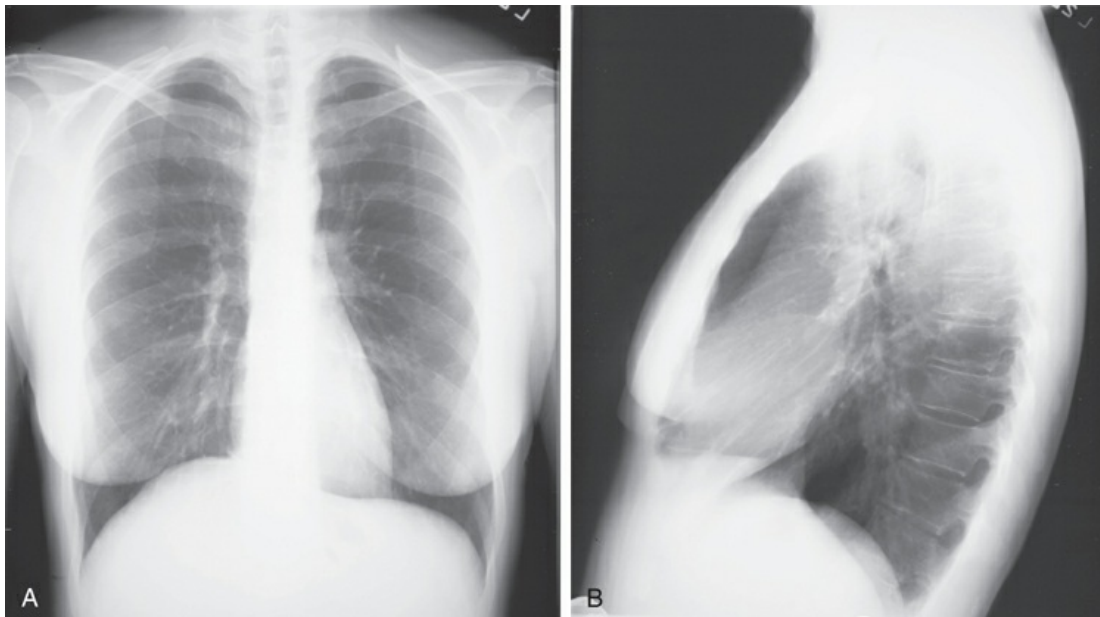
Normal chest radiograph. A, Posteroanterior view. B, Lateral view. Compare with Fig. 3.3 for position of each lobe.
